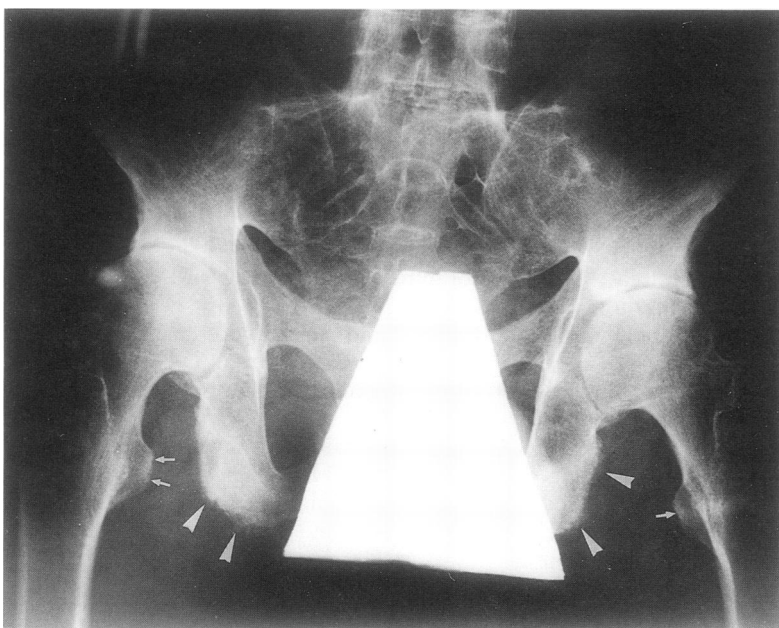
Pelvic radiograph shows fusion of both sacro-iliac joints. Whiskering is present at both ischial tuberosities and rami (arrowheads). Irregularity and sclerosis of the lesser trochanters are arrowed. Hip joints are concentrically narrowed.
